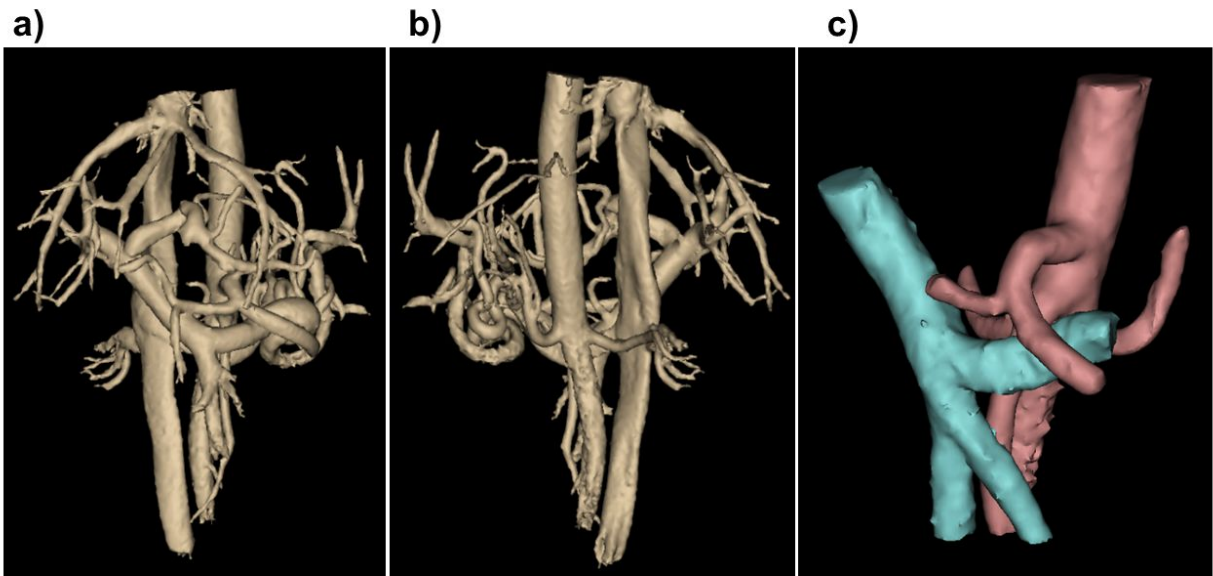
Phase contrast (PC) angiograms of the mesenteric vasculature created from 4D flow MRI complex difference data. Anterior (a) and posterior (b) views of the segmented angiogram for a healthy (61-year-old, male) control subject. Note the high vascular detail. “Trimmed” PC angiogram from the same subject, including only relevant venous (blue) and arterial (red) vasculature needed for quantitative analysis (c).
